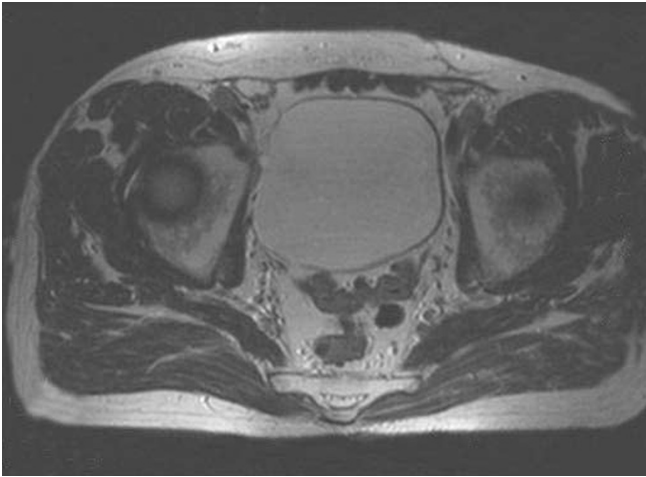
MR image of the pelvis, showing evident hypertrophy of the left piriformis muscle
